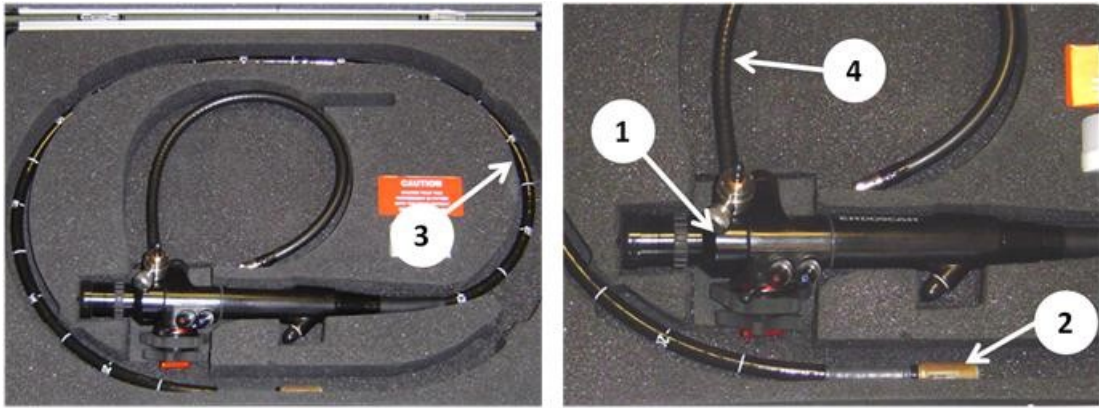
MRI compatible duodenoscope manufactured by Endoscan Ltd., showing (1) control handle, (2) distal tip, (3) flexible section and (4) light guide attachment.
